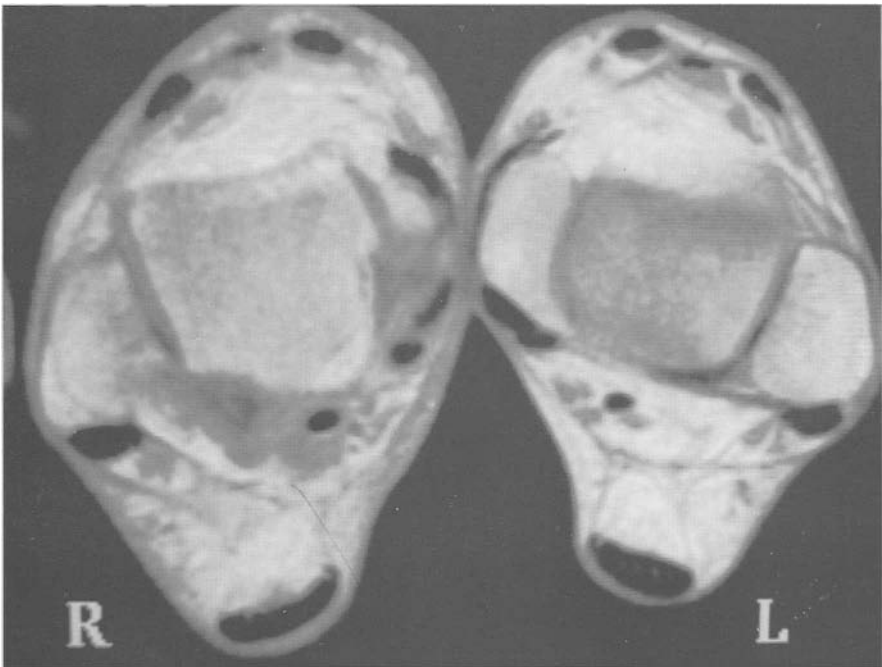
Same patient, MRI: T1 gadolinium (1995). Right pt: tenosynovitis and stage 2 tendinopathy. Left pt: stage 1 tendinopathy.
